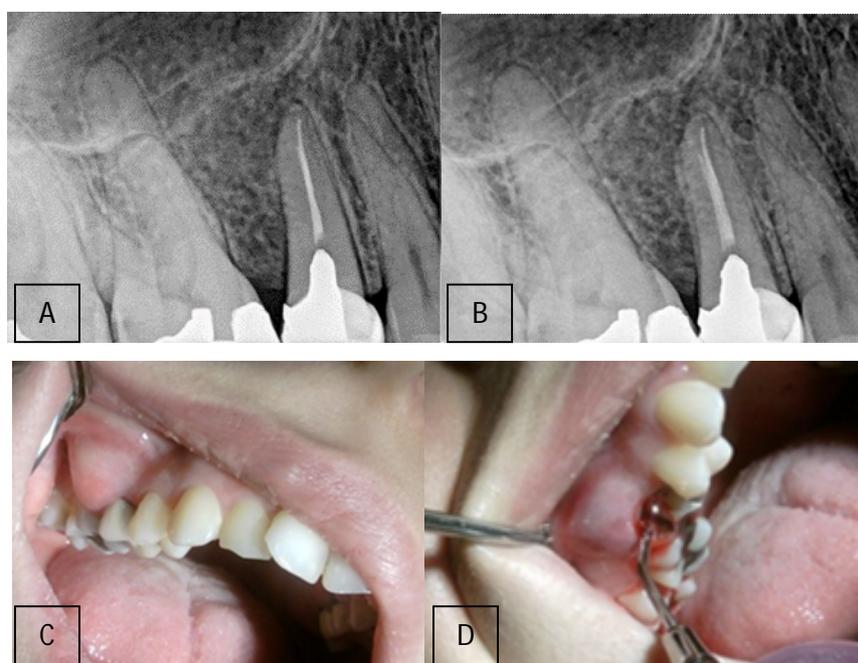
A. Preoperative periapical radiographic image. B. Mesially angulated periapical radiographic image. C. Preoperative clinical photography. D. Preoperative probing of the tooth.
